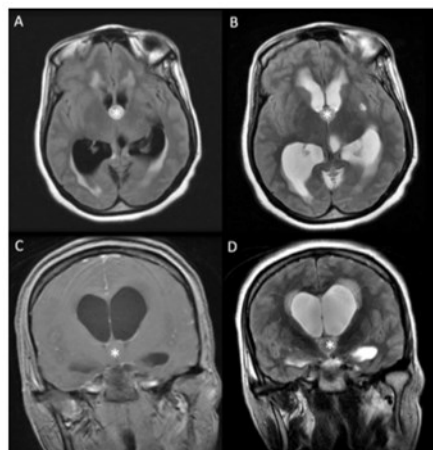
(Left): A colloid cyst (star) in the third ventricle seen in T1 weighted axial MRI (A), T2 weighted axial MRI (B), T1 weighted coronal MRI (C), T2 weighted coronal MRI (D). There is associated hydrocephalus with increase in size of the lateral ventricles.
